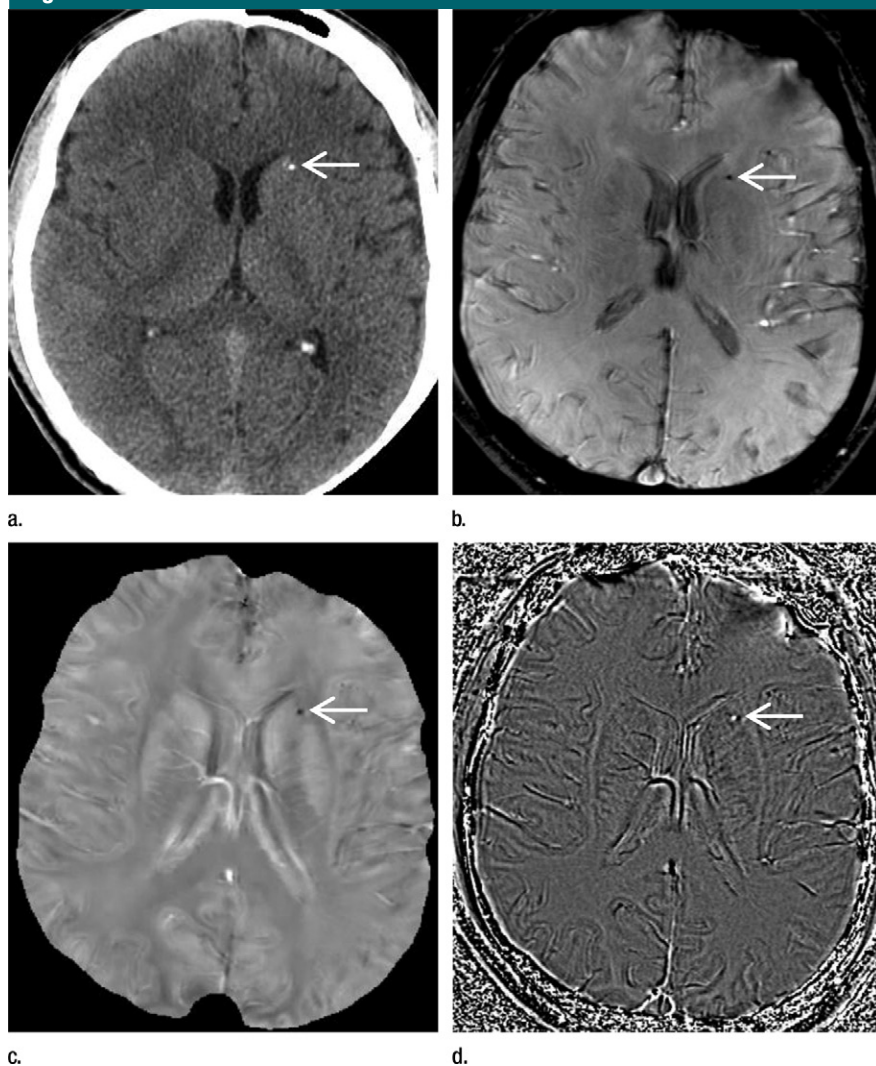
Calcification inside deep brain nuclei region in 26-year-old man with neurocysticercosis. A small calcified cysticercus granuloma (arrow) is seen at edge of left head of caudate nucleus and is (a) hyperattenuating on CT scan, (b) hypointense on T2*-weighted MR image, (c) diamagnetic on QSM image, and (d) diamagnetic on GRE phase image. Calcifications in choroid plexus on CT scan are absent on both QSM and GRE phase images owing to the difference in head orientations at CT and MR imaging.
